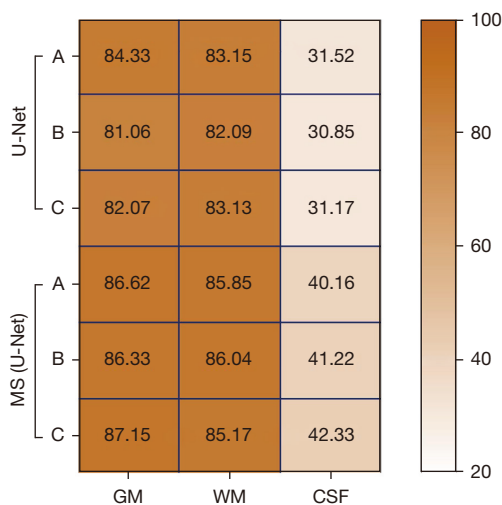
Comparison of J_s (%) values of MRI of the brain. MRI, magnetic resonance imaging; MS (U-Net), multiscale U-Net; GM, gray matter; WM, white matter; CSF, cerebrospinal fluid.
